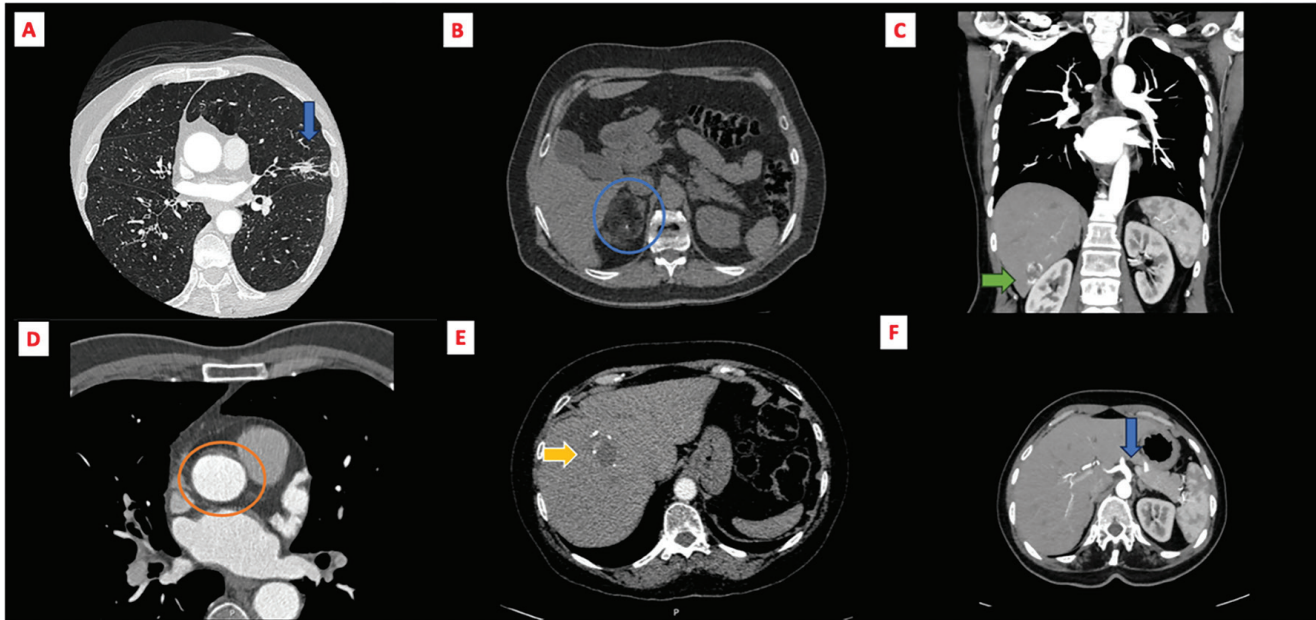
Examples of extracardiac findings detected during computed tomography angiography before atrial fibrillation ablation. A) Lung cancer (blue arrow) B) Surrenal adrenal myolipoma (blue circle) C) Hepatic cyst (green arrow) D) Mural thrombus in ascending aorta (orange circle) E) Hepatic cystic hydatid (yellow arrow) F) Coeliac arcuate ligament (blue arrow)
